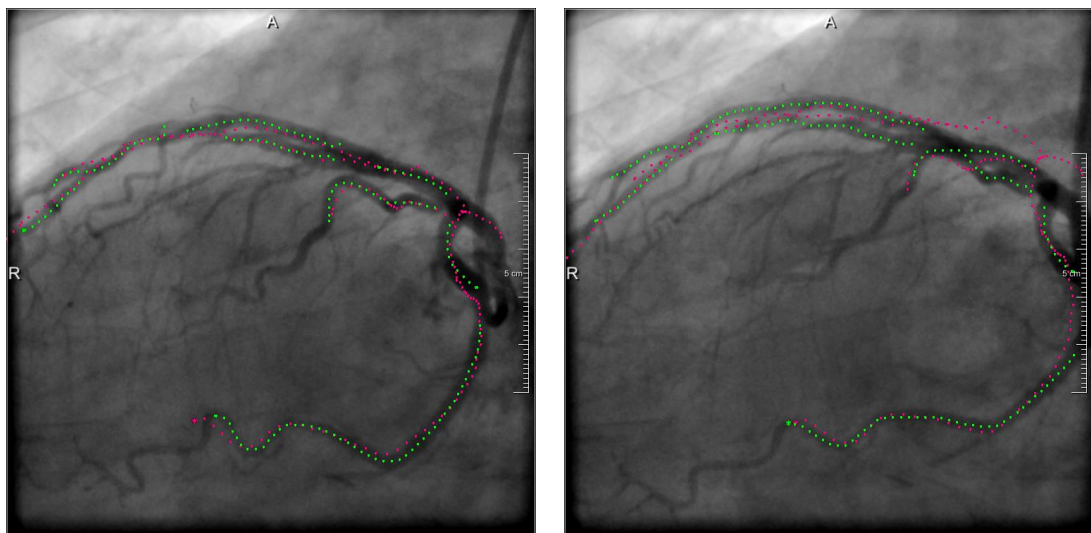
Examples of two images used for the evaluation of the alignment quality. These are X-ray frames of the time-sequence 3.2 where the vessel centerlines are highlighted: the green is the manual annotated centerline in X-ray and the pink is the closest registered and projected centerline from the CTA model (obtained by the exhaustive-search process). They represent the best (left) and the worst (right) alignment according to the established ranking.
